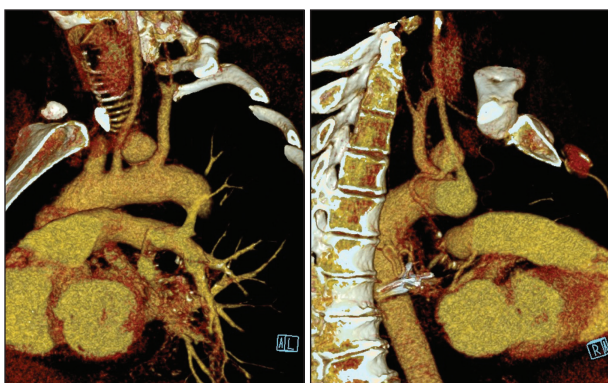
A three-dimensional reconstruction of a CTA showing the aneurysmatic origin of an aberrant bronchial artery.
